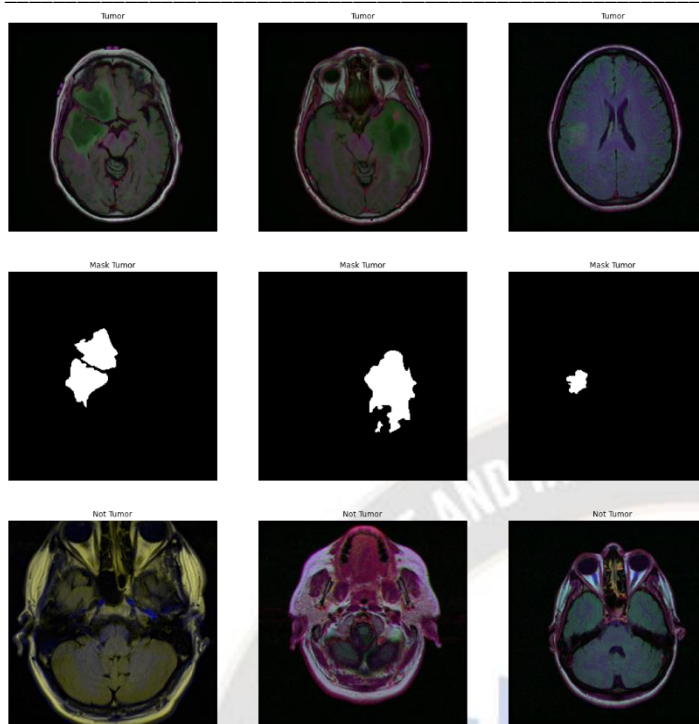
Brain MRI image and its tumor mask
